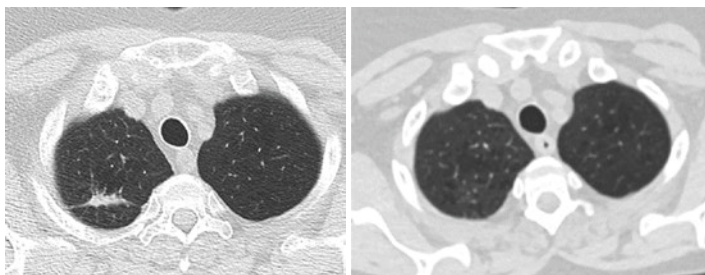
Right upper lobe spiculated nodules with pleural tale looks like lung cancer but resolves on short interval follow-up CT scan of the chest
